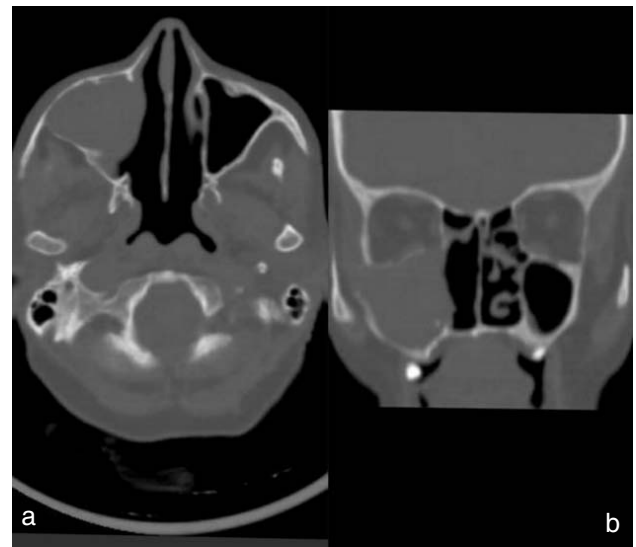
(A and B): Axial and coronal CT scan bone window images showing pressure erosion of walls of right maxillary sinus.
